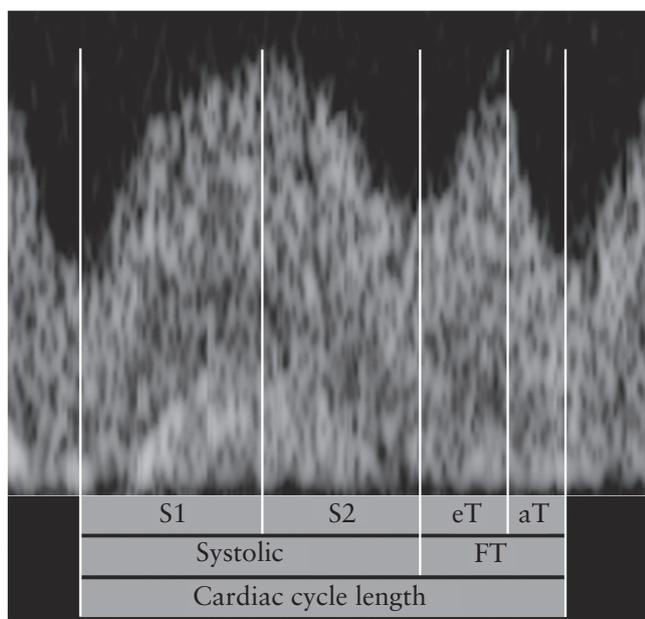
Ductus venosus Doppler waveforms showing acquisition of time intervals. S1, acceleration time during ventricular systole, measured from the nadir of the a-wave to the peak of systole; S2, deceleration time during end-systolic ventricular relaxation, measured from the peak of systole to the nadir between systole and diastole; Systolic, sum of S1 and S2; eT, early diastolic filling time, measured from the onset of diastolic filling to the beginning of the fast deceleration caused by atrial contraction; FT, total diastolic filling time, measured from the onset of diastolic filling to the nadir during atrial contraction; aT, late diastolic filling time, obtained by subtracting eT from FT. Relative time intervals are calculated by dividing the time interval by the total cardiac cycle length: $S1 (\%) = S1 (\text{ms}) / \text{cardiac cycle length (ms)}$; $S2 (\%) = S2 (\text{ms}) / \text{cardiac cycle length (ms)}$; $eT (\%) = eT (\text{ms}) / \text{cardiac cycle length (ms)}$; $aT (\%) = aT (\text{ms}) / \text{cardiac cycle length (ms)}$; $FT (\%) = FT (\text{ms}) / \text{cardiac cycle length (ms)}$; $\text{Systolic} (\%) = \text{Systolic (ms)} / \text{cardiac cycle length (ms)}$. Reproduced from Wohlmuth *et al.*²¹ with permission.
